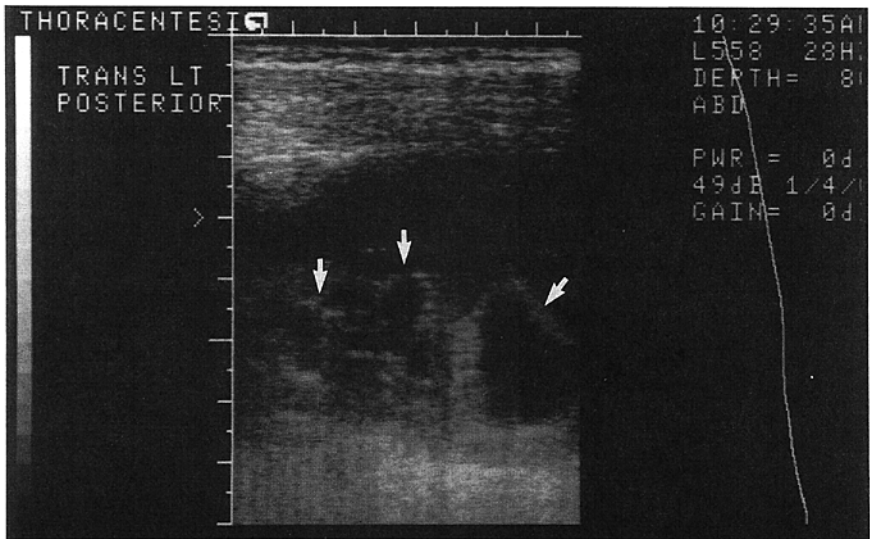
Empyema with multiple septations. Real-time high-resolution ultrasound demonstrates a complex pleural effusion with multiple septations (arrows). Three thoracostomy tubes were required for drainage of the effusion. The septated nature of the empyema was not detected from chest radiographs.
